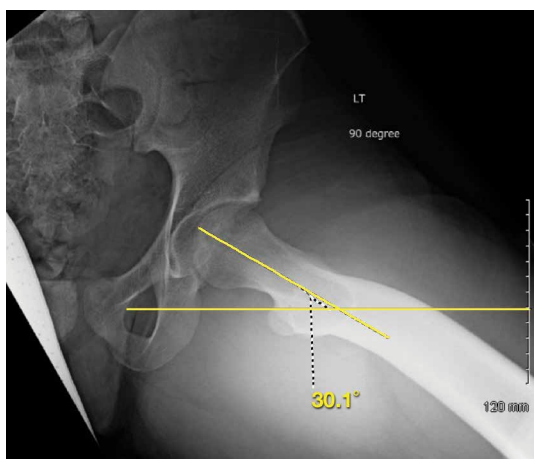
Femoral version. Dunn lateral radiograph of an 18-year-old man with 30° femoral anteversion. As originally described by Dunn, measured angle is formed by center line of femoral neck and line parallel to edge of film. On this radiograph, angle measurement does not take into account posterior transcondylar axis. With transcondylar axis, angle is expected to be <15°.
